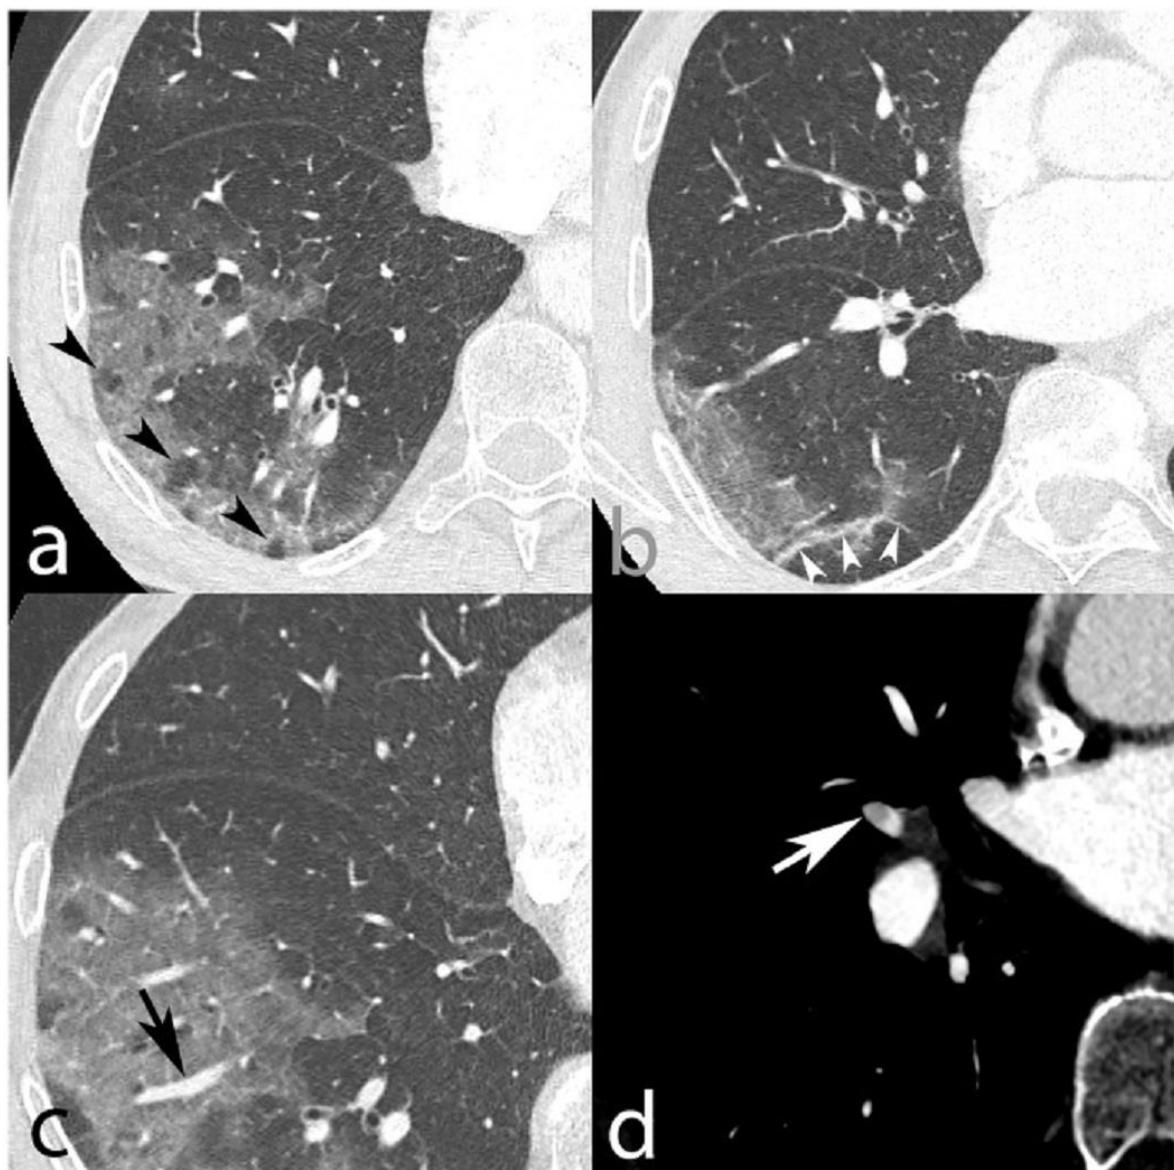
Axial CT pulmonary angiography in lung window, from a 75-year-old man, who was diagnosed with COVID-19. Images show multifocal predominantly peripheral ground-glass opacities in the right lung base (a–c), with associated vacuolar sign (black arrowheads, a), fibrous streaks (white arrowheads, b), and vascular dilation sign (black arrow, c) suggestive of SARS-CoV-2 infection. In the soft tissue window, a filling defect partially outlined by contrast agent was found in the lateral branch of the right middle lobar artery, indicating acute pulmonary embolism (white arrow). Acute pulmonary embolism was unlikely to be caused by in-situ thrombosis due to interstitial COVID-19 injury since the parenchyma in the right middle lobe was normal (b). [Reproduced from: Rotzinger DC, Beigelman-Aubry C, von Garnier C, Qanadli SD. Pulmonary embolism in patients with COVID-19: Time to change the paradigm of computed tomography. Thromb Res 2020;190:58-59. doi:10.1016/j.thromres.2020.04.011]
